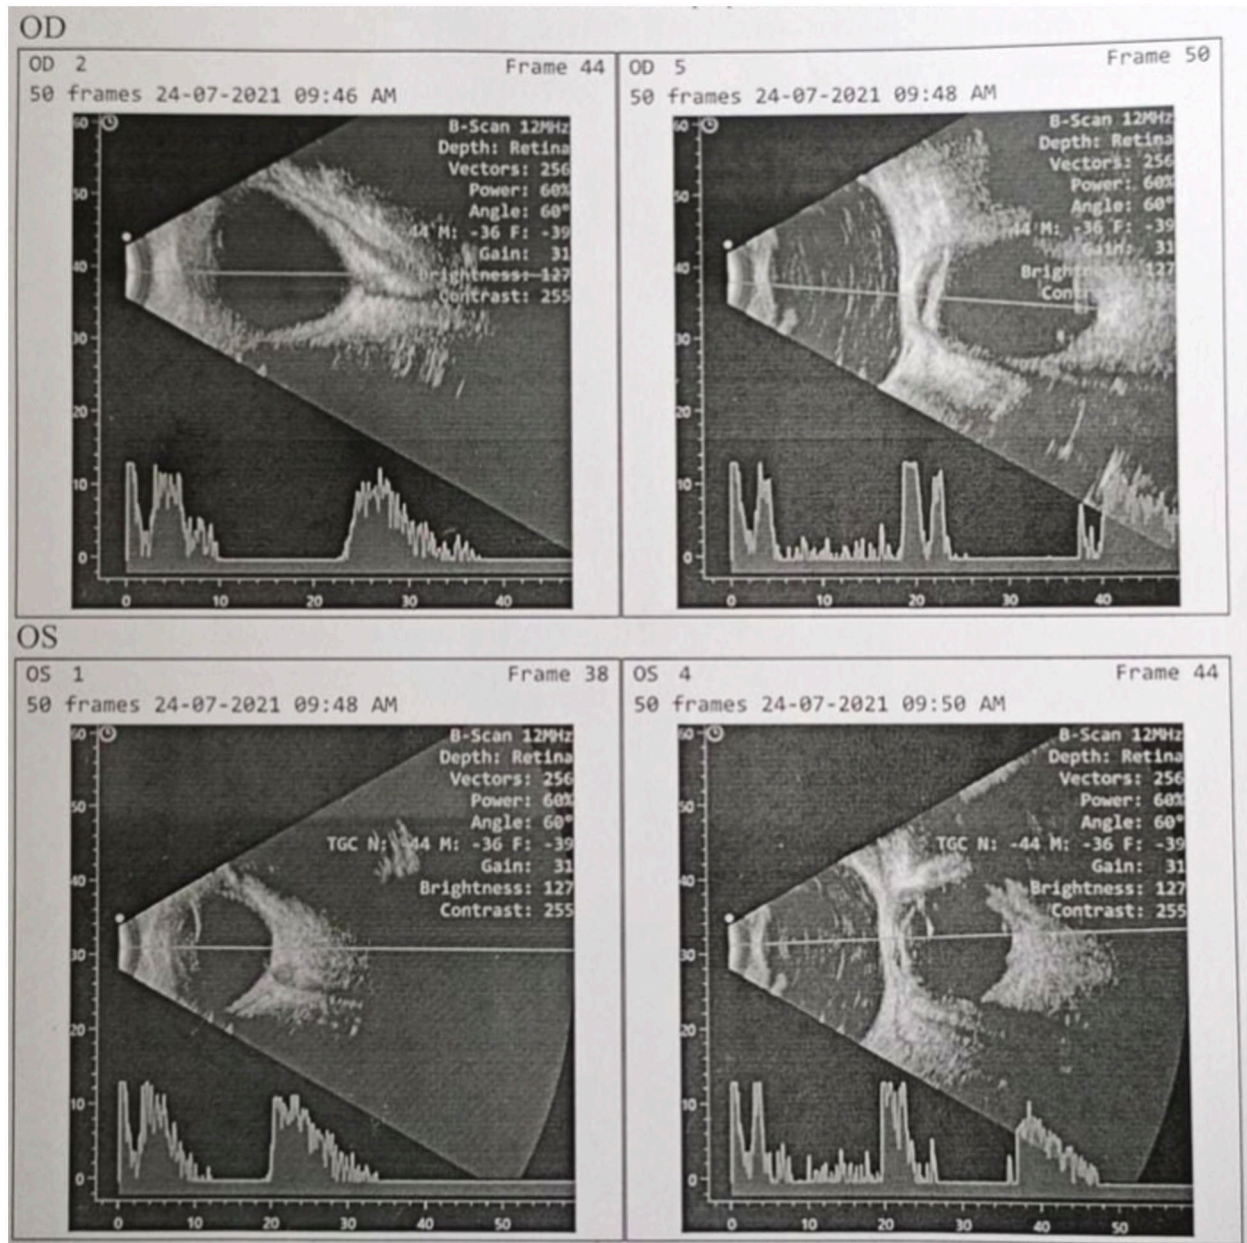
B Scan ultrasonography showing features of Right eye (OD) and left eye (OS).
